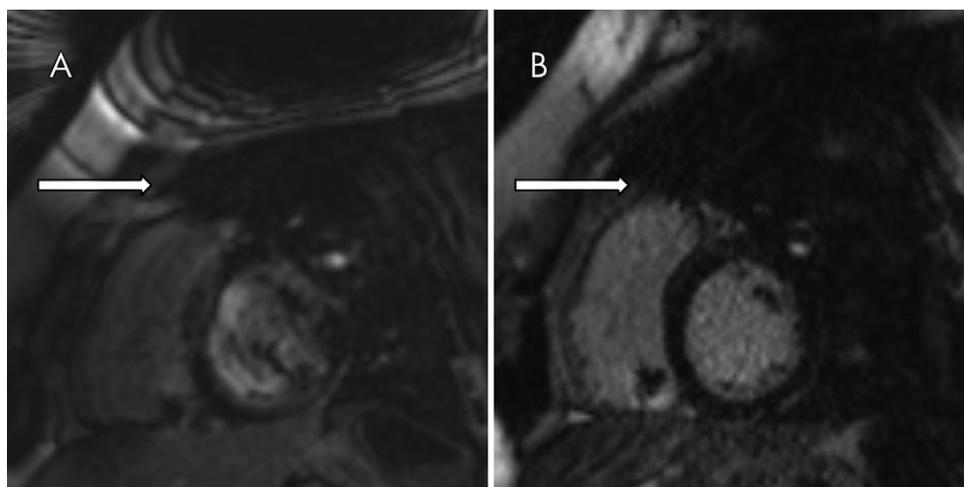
Images in a 28-year-old woman with a Medtronic Evera MRI XT single-chamber implantable cardiac defibrillator imaged with a Siemens Magnetom Aera 1.5-T unit. Short-axis delayed enhancement images with artifacts (arrow) acquired with, *A*, balanced steady-state free precession sequence and, *B*, gradient-echo sequence.
